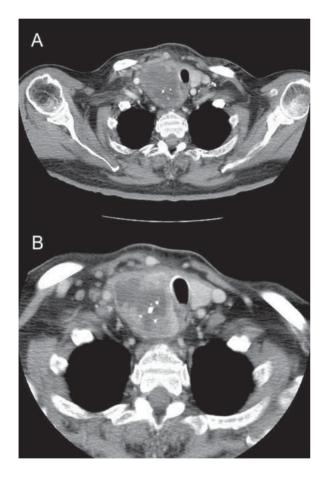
Neck CT on admission — neck mass localised around the right thyroid lobe ($70 \times 40 \times 30$ mm) extending to mediastinum, compressing trachea and oesophagus (A); after four weeks of antibiotic treatment — suspicion of abscess formation, no shrinkage of the right thyroid lobe compared to previous examination (B)
